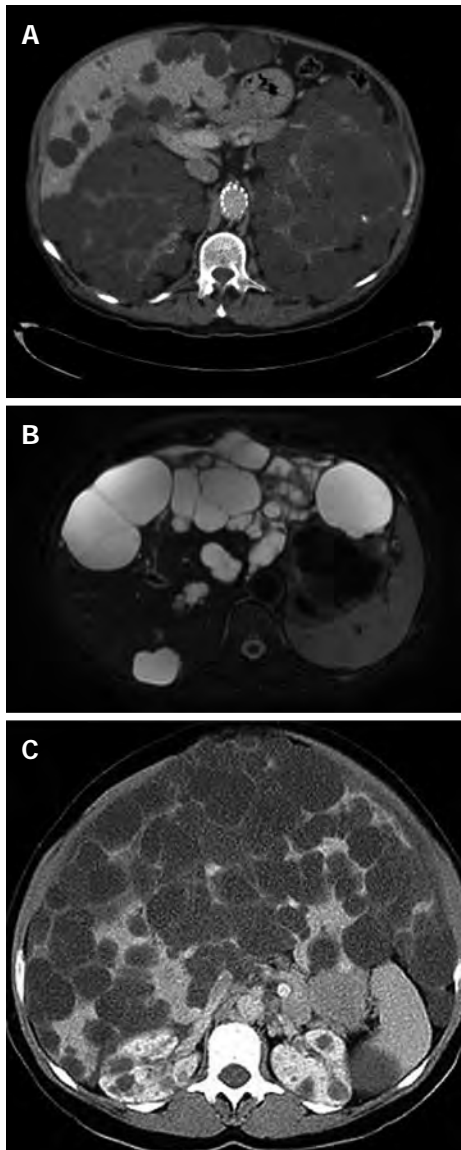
Gigot's classification relies on imaging findings and was designed to identify the best candidates for fenestration of symptomatic cysts. A: Intravenous contrast enhanced computerized tomography (CT) of a patient affected by polycystic liver and renal disease. The cysts appear hypodense with smooth and regular walls; B: T2 magnetic resonance imaging of a patient with multiple hepatic cysts. The cystic fluid appears bright on T2 images; C: Abdominal CT of a patient affected by Gigot III cystic liver disease.
